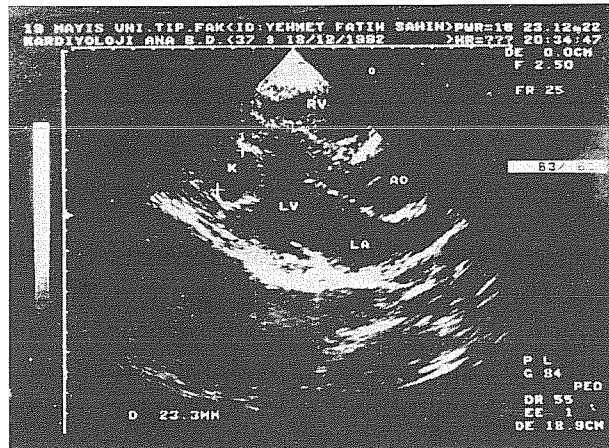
Two-dimensional echocardiography: An oval mass involving the ventricular wall.
